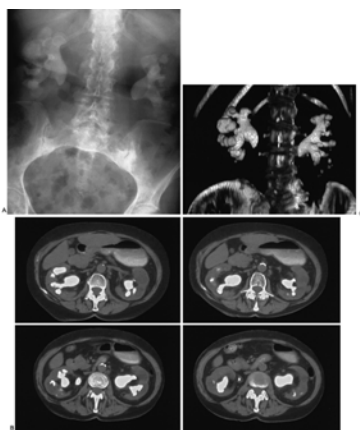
A: Plain abdominal film in this patient with significant renal insufficiency and proteus urinary infection reveals extensive, fully mature staghorn calculi bilaterally. Anatrophic nephrolithotomy is a reasonable approach compared with the option of multiple percutaneous and shock wave procedures. B: Standard computed tomography scan without contrast helps delineate the stone and the thickness of the overlying parenchyma. C: More recently, three-dimensional reconstruction has been used for more precise anatomic definition.
